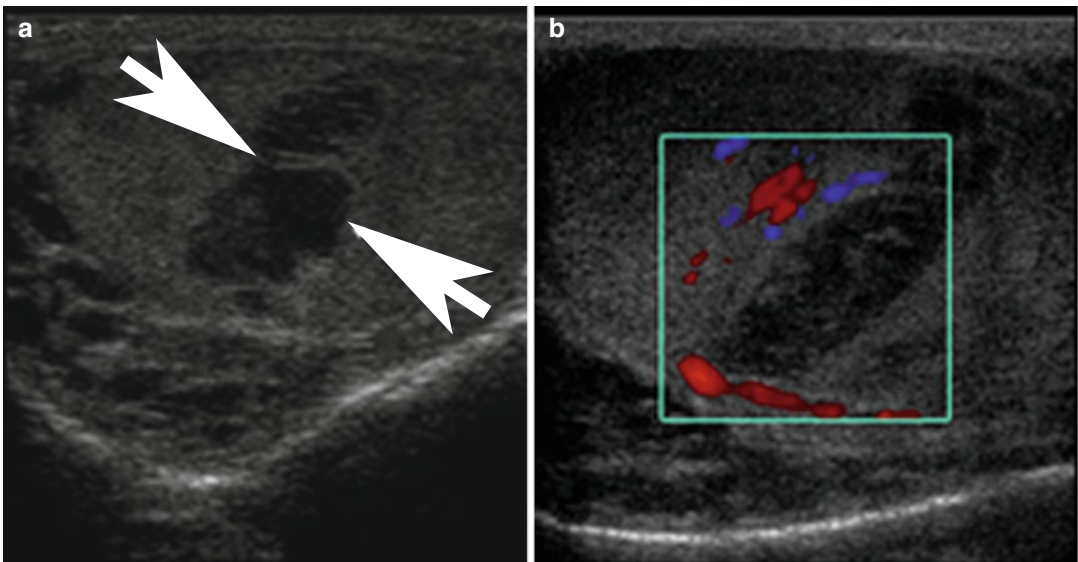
Patient with scrotal trauma and resultant fracture. (a) Ultrasound image shows a well circumscribed hypoechoic area (*arrowheads*). (b) On the corresponding color Doppler
